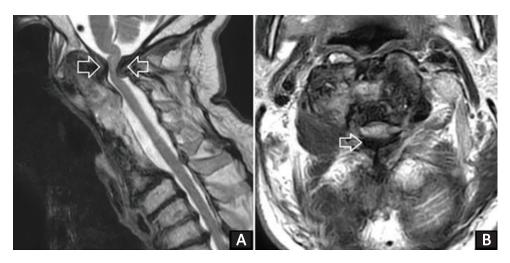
A: Sagittal T2-weighted magnetic resonance image (MRI) showed previous decompression site (C2–C6) and stenosis (arrows) at C1–C2 level. B: Axial T2-weighted MRI showed cluttered fusion and posterior ligamentous thickening (arrow) at C1–C2 level.
